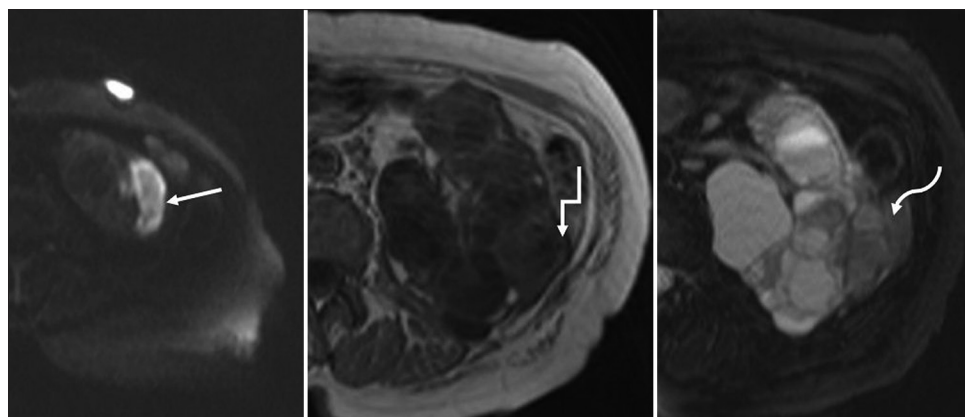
DW-MRI showing left renal cyst with remarkably high signal intensity, indicating that the contents of cyst show restricted diffusion (straight arrow). T1-WI showing the low-signal in corresponding cyst (step arrow) and Fat-saturated T2WI showing the low-signal cyst (curved arrow)
